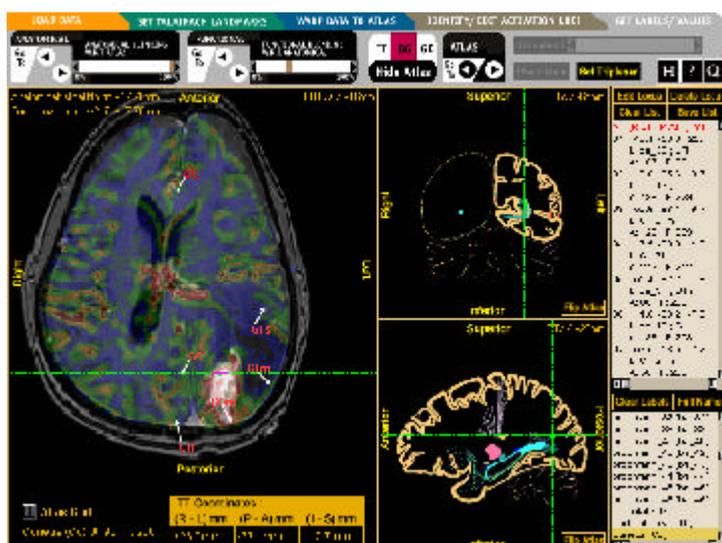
The *Brain Atlas for Functional Imaging*. The MRI anatomical dataset is fused with a color-coded functional dataset. The region of the tumor is labeled by using the atlas.
